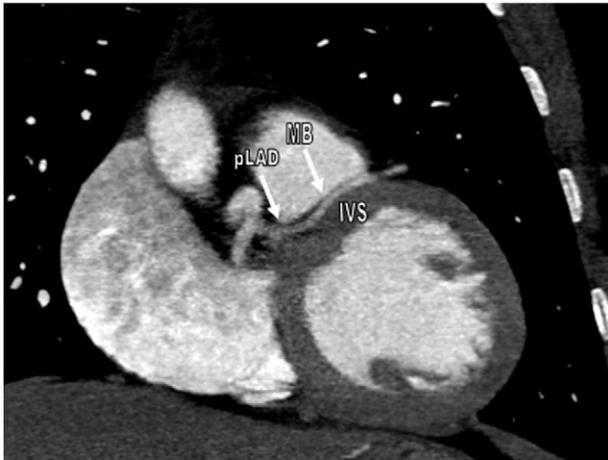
Multiplanar image of MSCT coronary angiography shows myocardial bridging into the interventricular septum (MSCT: Multislice computed tomography, pLAD: proximal LAD, MB: myocardial bridging, IVS: interventricular septum).
